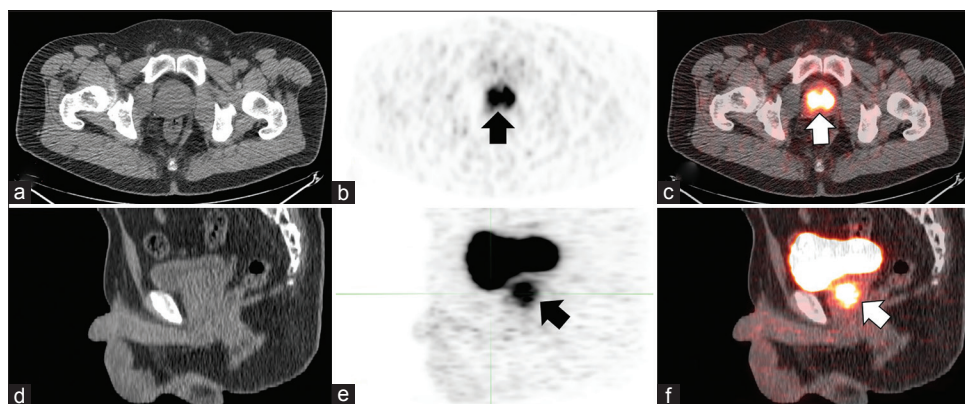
Intense Gallium-68 DOTA-Tyr3-octreotate uptake is seen diffusely throughout the prostate gland (arrows) (maximum standard uptake value = 17.4). (a-c) show the axial views, and panels (d-f) show the sagittal views of the computed tomography, positron emission tomography, and positron emission tomography/computed tomography fusion, respectively
